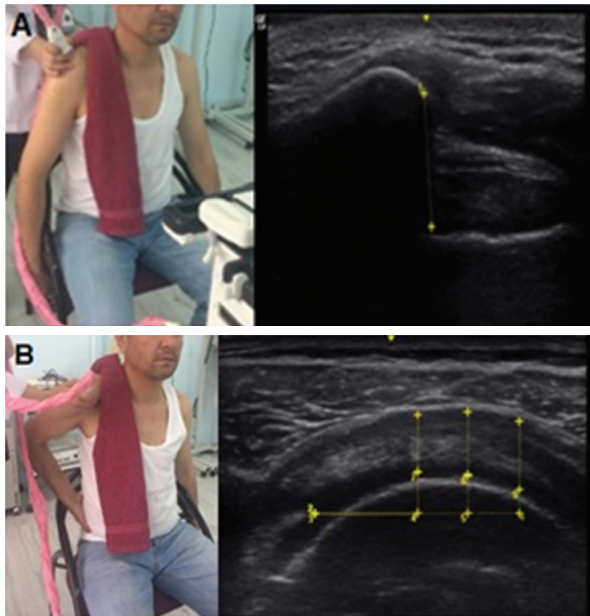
Ultrasonography measurement. A. Acromiohumeral distance assessment with ultrasonography, and ultrasound measurement of the acromiohumeral distance from the acromial tip to the humeral head. B. Supraspinatus tendon thickness assessment with ultrasonography and ultrasound measurement of the tendon thickness taken at 10, 15, and 20 mm lateral to the biceps tendon (transverse view).
